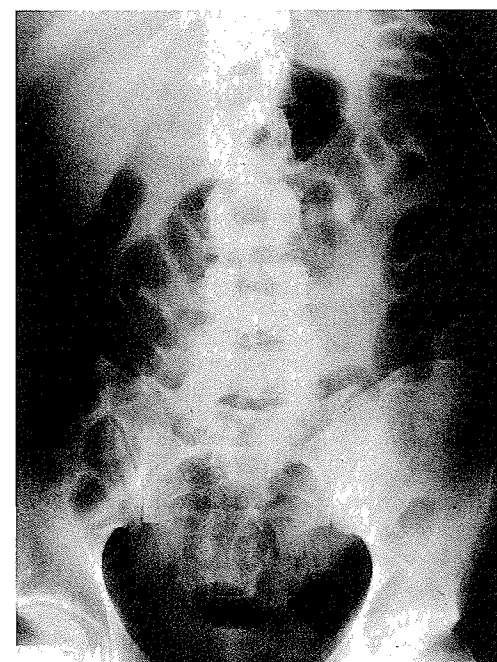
Abdominal radiograph demonstrating an abnormal bowel gas pattern due to enlargement of the liver in a patient with hepatic abscess.
